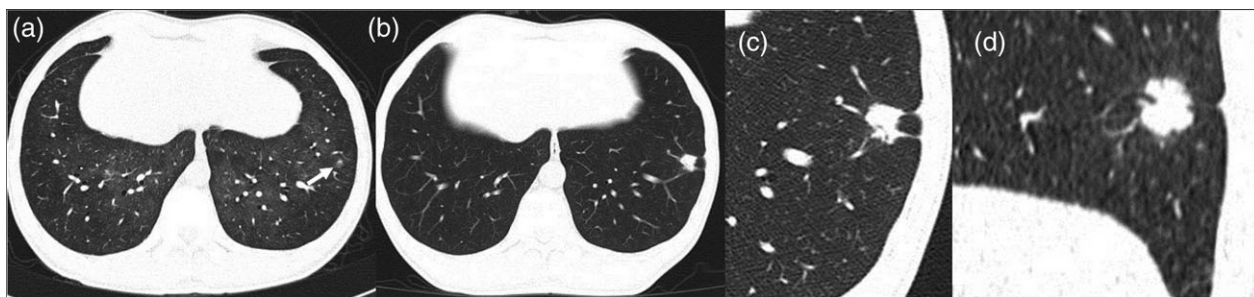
A 46-year-old male treated with highly active antiretroviral therapy for 32 months complained of chest pain for two months. (b–d) A solid nodule with lobulation and pleural indentation in the left lower lobe was noticed in the lung window on chest computed tomography scan, which was more prominent and larger than it was two years before (a), when it was inconspicuous (white arrow) in the set of *Pneumocystis carinii* pneumonia. Adenocarcinoma was confirmed by wedge resection (stage Ia).
